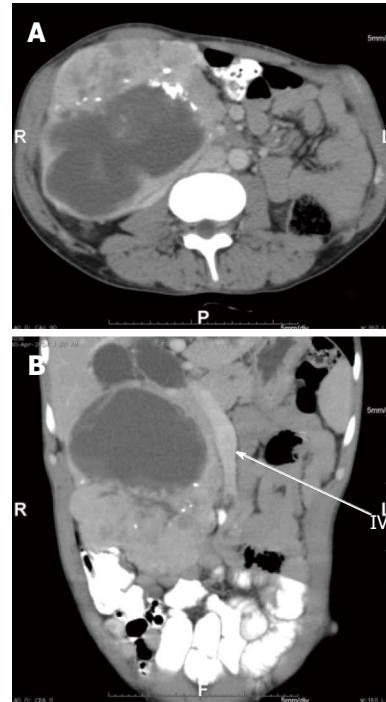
Computed tomography abdomen showing tumour encasing second part of duodenum and dilated common bile duct.
